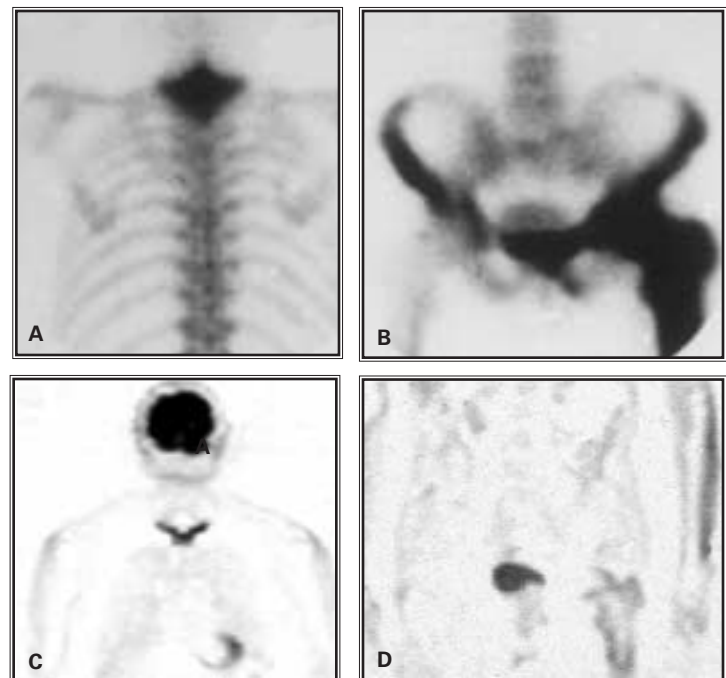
A and B: Tc-99m MDP bone scan demonstrates Paget's disease in left femur and upper thoracic spine. C and D: Avid activity is also seen on FDG-PET scan.
